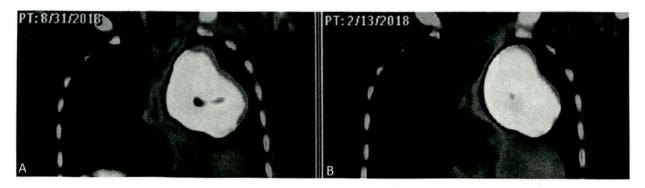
Comparison of ⁶⁸Ga-DOTATATE PET-CT scans dated [A] August 2018 and [B] February 2018.
